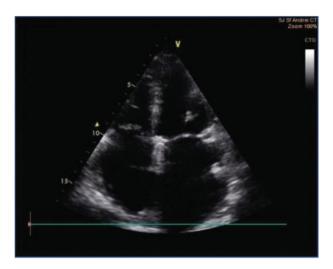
Contrast-enhanced echocardiogram. Apical four-chamber view before contrast injection.
